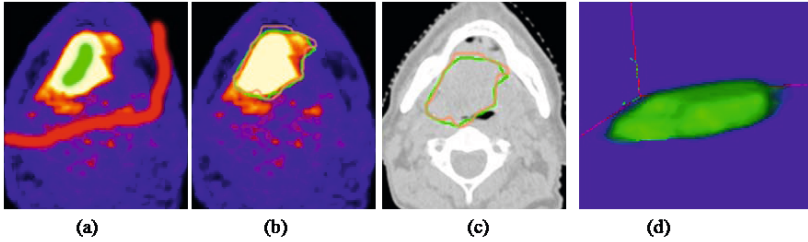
A tumor segmentation example. (a) 2-D slice of 3-D PET image with seeds highlighted. The read line and the green line were background and foreground seeds. (b) The results in PET image. Manual segmentation were showed with orange and our results were showed with green. (c) The results in CT image. (d) 3-D representation of the tumor (green).
